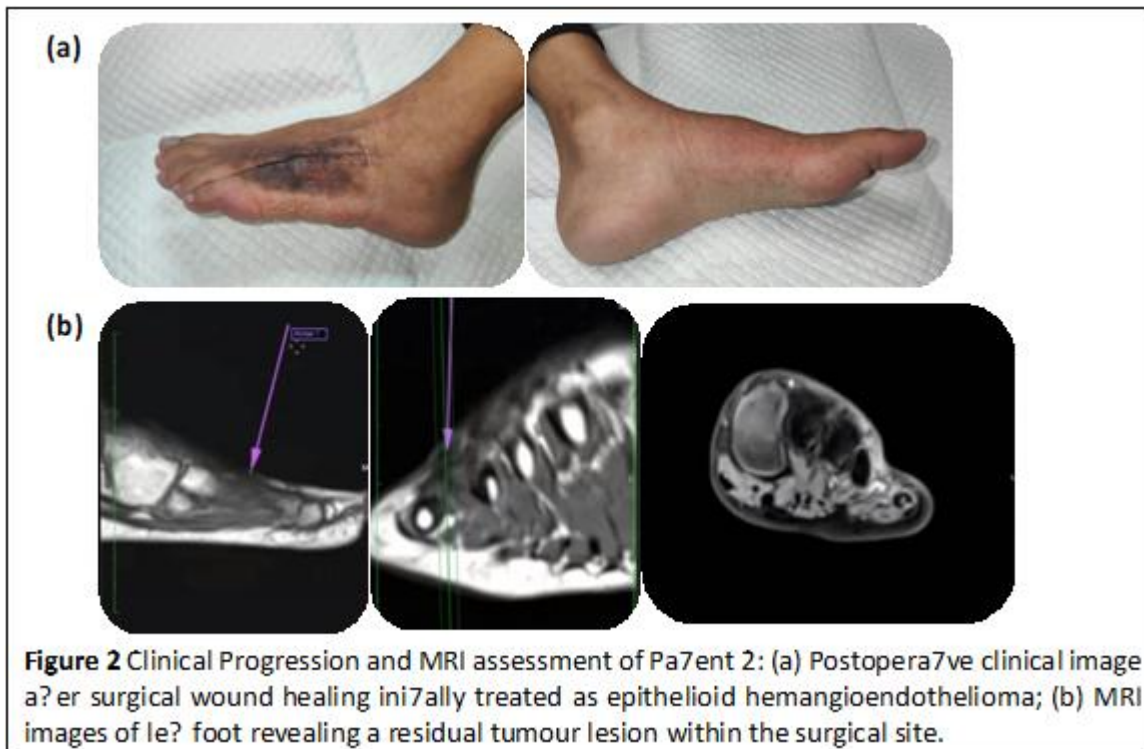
Clinical Progression and MRI assessment of Patient 2: (a) Postoperative clinical image after surgical wound healing initially treated as epithelioid hemangioendothelioma; (b) MRI images of left foot revealing a residual tumour lesion within the surgical site.
